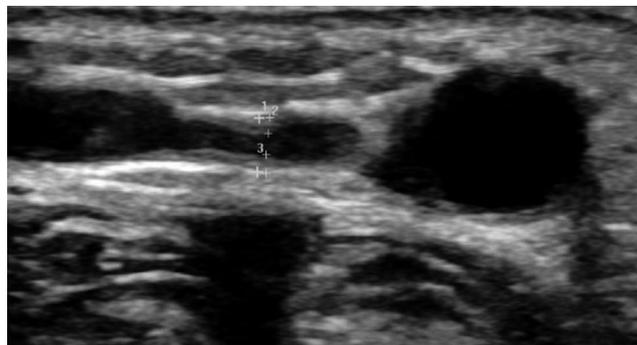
B-mode ultrasound image of a juxta-anastomotic stenosis of a radiocephalic fistula. Measurements of IMT, outer to outer vein diameter and luminal diameter are shown
